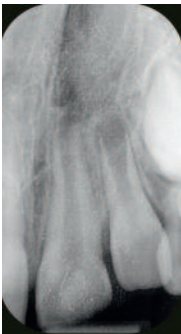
Postoperative radiograph of the pulp cap with Biodentine™, showing a material with moderate radiopacity
